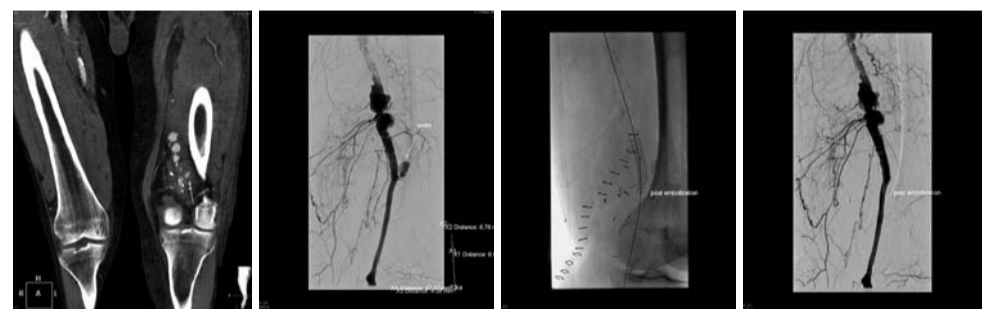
72-year-old man. Popliteal aneurysm open surgery repair, one week later patient arrives in the ER with swallowed knee and at US 5x5x10 cm hematoma. (a) CT showing bleeding at the upper anastomosis, (b) Angiography showing the bleeding, (c,d) Post-deployment angiography, Viabahn 8x50 mm.
